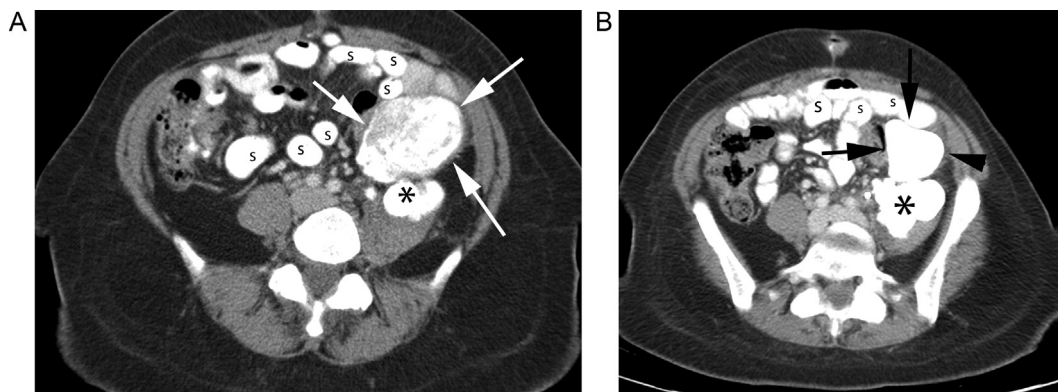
Low grade serous carcinoma on serial CT. Patient 2 is a woman in her 60s. (a) Initial CT with oral and intravenous contrast shows a calcified solid mesenteric mass (arrows). Oral contrast is in small bowel loops (s). A calcified left psoas mass (\*) is partially imaged. (b) CT 4 months later shows increased calcification of the mesenteric mass (arrows). Oral contrast is in small bowel loops (s). The calcified left psoas mass (\*) is again imaged.
